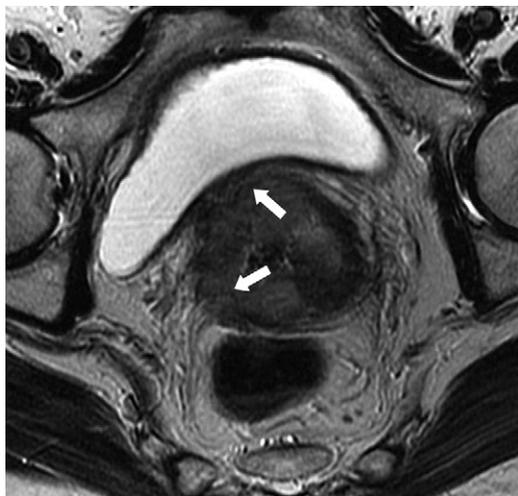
Image shows uterine cervical cancer with parametrial involvement. Axial oblique fast spin-echo T2-weighted image in a woman clinically staged as IB shows tumor that extends beyond dark stromal ring of cervix into adjacent parametria (arrows) corresponding to stage IIB.
